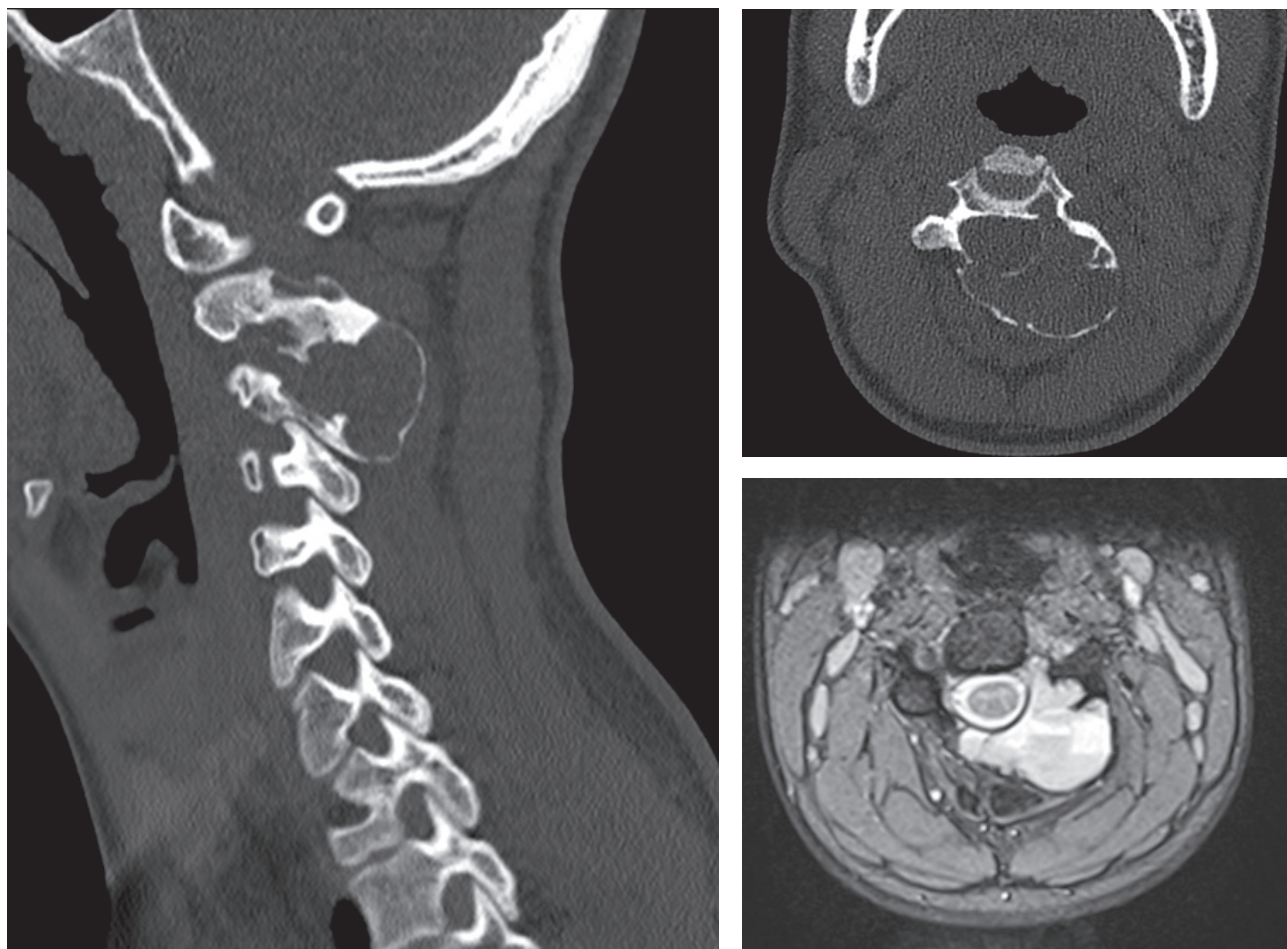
a) Cervical spine CT scan in sagittal plane demonstrating aneurysmal bone cyst (ABC) of C2 and C3 vertebrae b) Cervical spine CT scan in axial plane presenting expansive lytic bone lesion c) Cervical spine MRI scan demonstrating typical appearance of lytic osseous lesion with intratumoral septa, with pockets of different stage bleeds.
